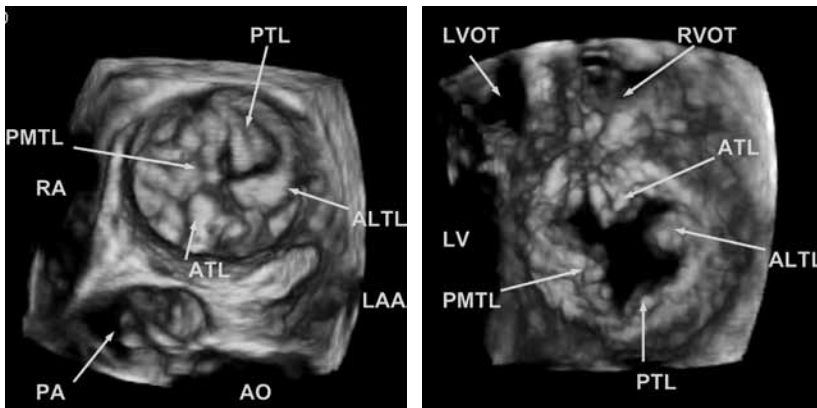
The RT3DE en face view from the left atrium to the tricuspid valve (TV) (left) and from the apex to the TV (right) in the same case shown in Figures 22 and 23. The TV appears to have four leaflets. Note the abnormal left and anterior position of the aorta (AO) in relation to the pulmonary artery (PA). Naming of abnormal anatomic structures, as in this case the abnormal TV, according to its position in the patient's heart (anterior-posterior, superior-inferior and left-right) is the best way to describe these very rare anomalies. Orientation in the heart is made much easier with 3D echocardiography when compared with 2D echocardiography. LAA left atrial appendage, PTL posterior tricuspid leaflet, PMTL posterior-medial tricuspid leaflet, RA right atrium, ALTL antero-lateral tricuspid leaflet, ATL anterior tricuspid leaflet, LVOT left ventricular outflow tract, RVOT right ventricular outflow tract, LV left ventricle.
